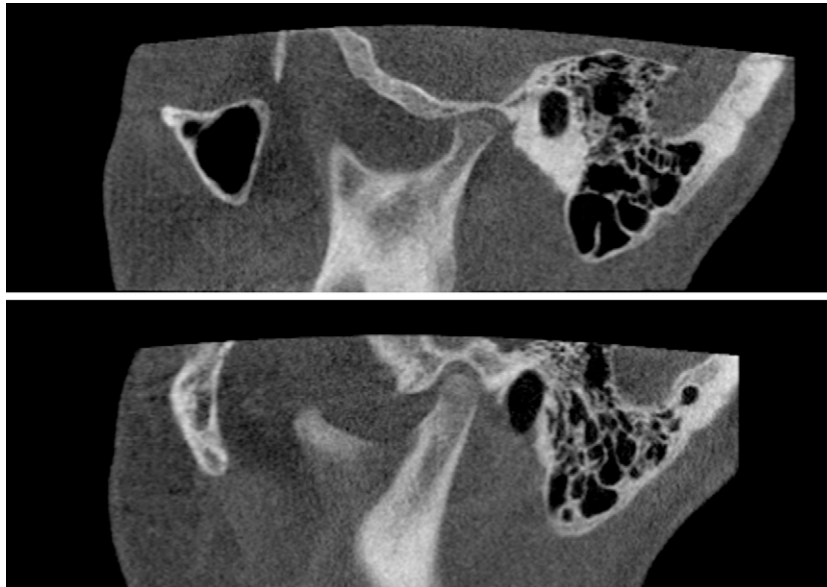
CBCT of juvenile idiopathic arthritis (female, 13 years): deformed (remodelled) right joint: rather flat fossa/eminence and condyle, without cortical erosion (upper) and normal left joint for comparison (lower).
